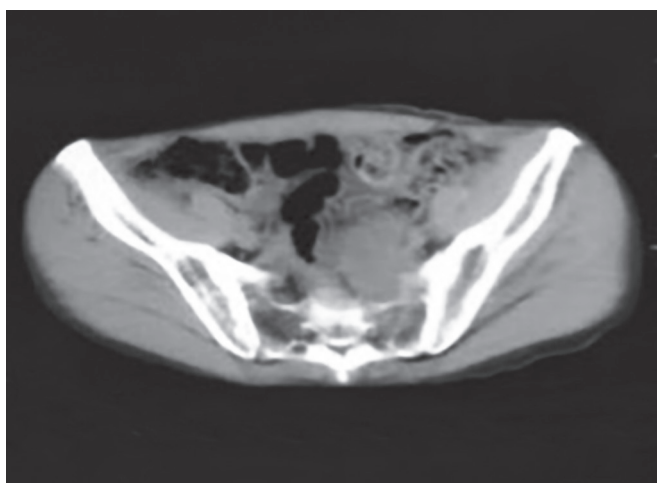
Selected PET/CT image highlighting compression
